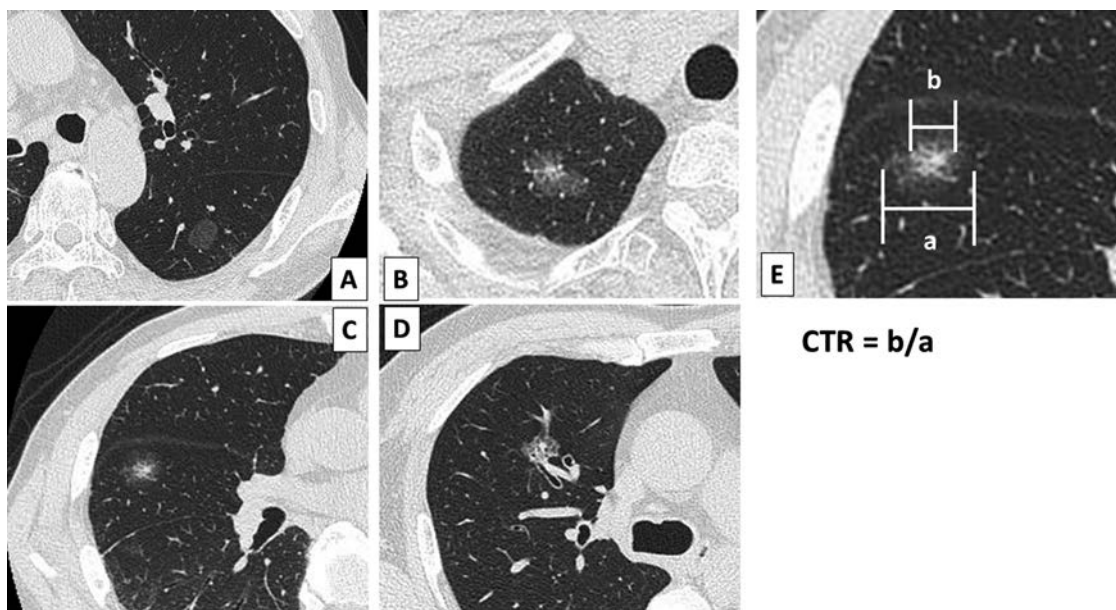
Representative images of classification according to the consolidation-to-tumor ratio (CTR). (A) CTR=0 (pure GGN; i.e., nodule containing only ground-glass opacity), (B) CTR >0 and ≤ 25 , (C) CTR >25 and ≤ 50 , and (D) CTR >50 and ≤ 75 . (E) The CTR was defined as the ratio of the maximum size of consolidation to the maximum tumor size on thin-slice computed tomography.
